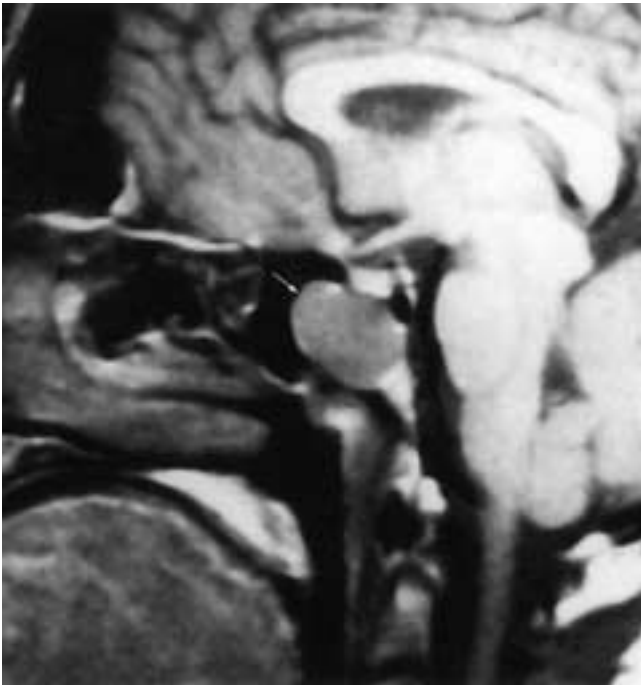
Sagittal T1-weighted MR image shows a solitary nonobstructing retention cyst or polyp (arrow) in the sphenoid sinus. This is the type of lesion that was formerly referred to as a *mucocoele* in the older literature.
